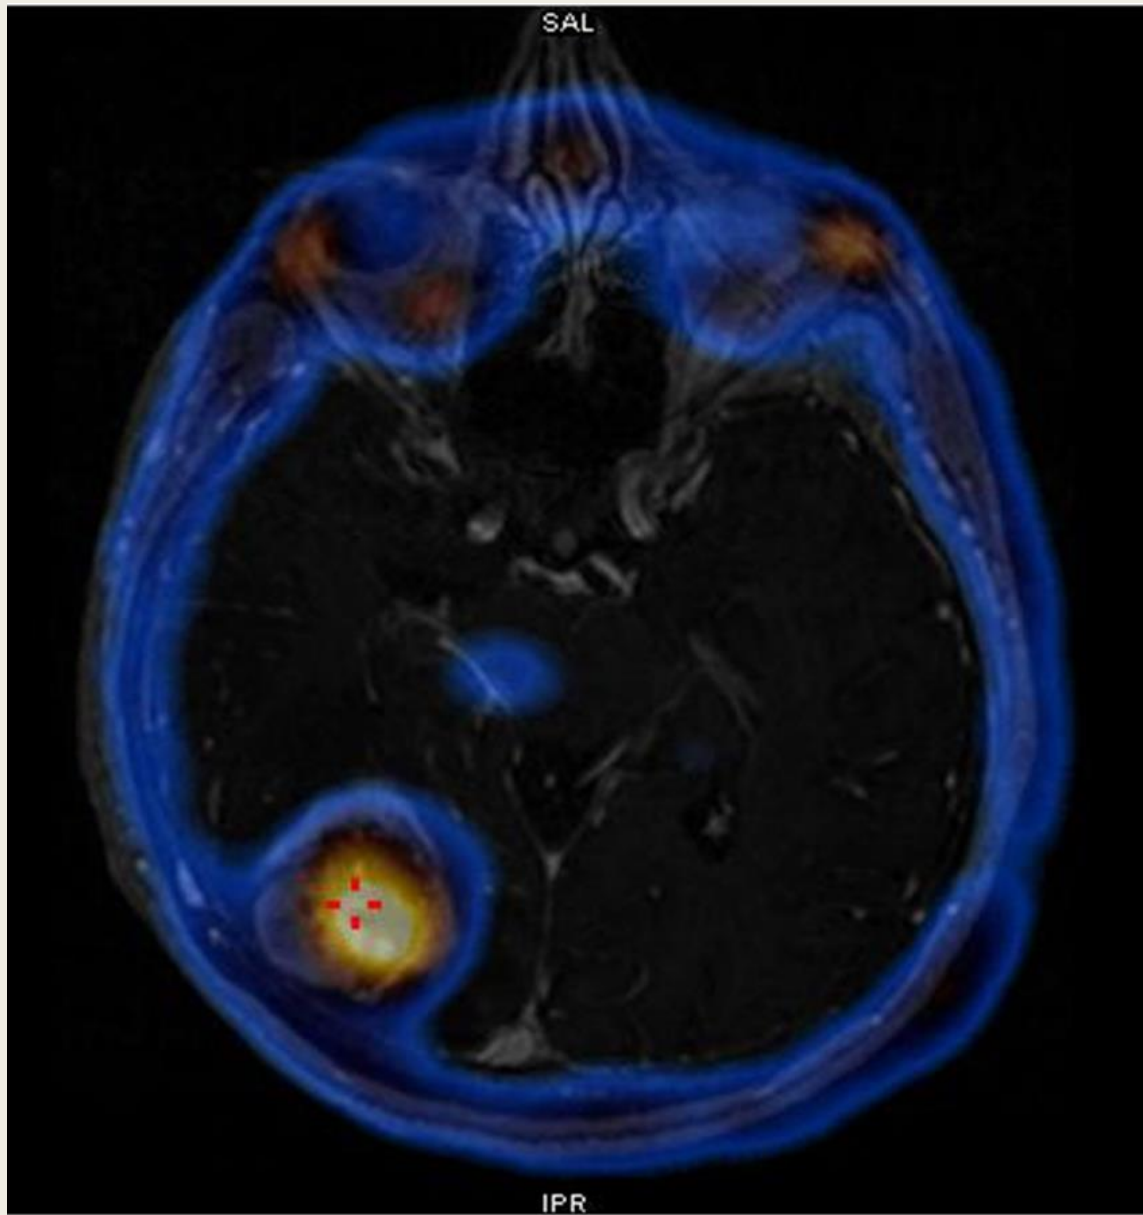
Brain SPECT and MRI fusion image of gliosarcoma
